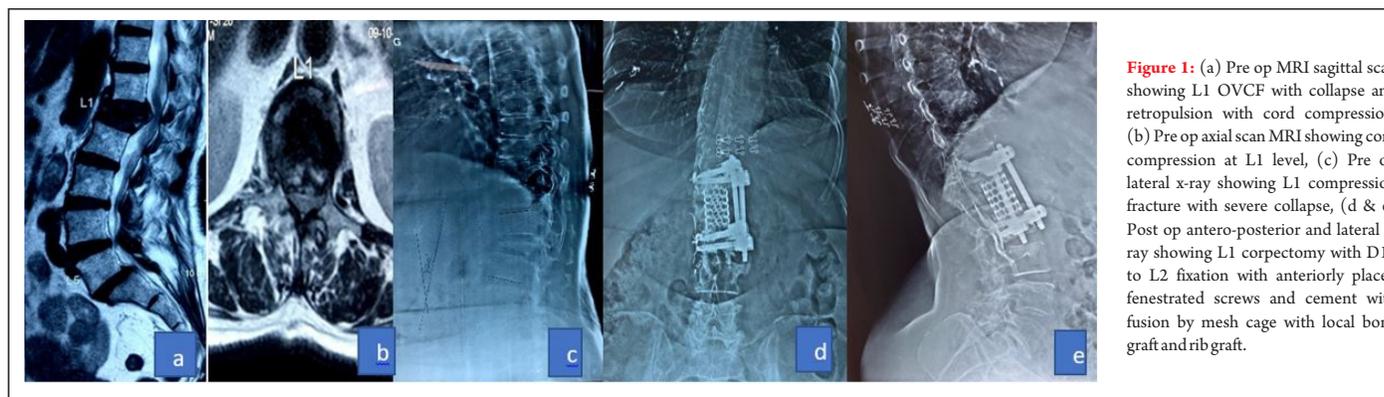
(a) Pre op MRI sagittal scan showing L1 OVCF with collapse and retropulsion with cord compression, (b) Pre op axial MRI showing cord compression at L1 level, (c) Pre op lateral x-ray showing L1 compression fracture with severe collapse, (d & e) Post op antero-posterior and lateral x-ray showing L1 corpectomy with D12 to L2 fixation with anteriorly placed fenestrated screws and cement with fusion by mesh cage with local bone graft and rib graft.
